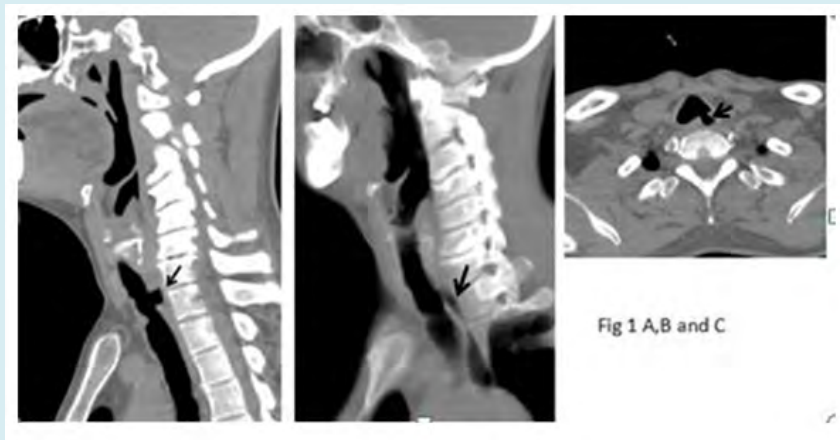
CT images in sagittal and axial planes, Arrows indicate air in esophagus.
